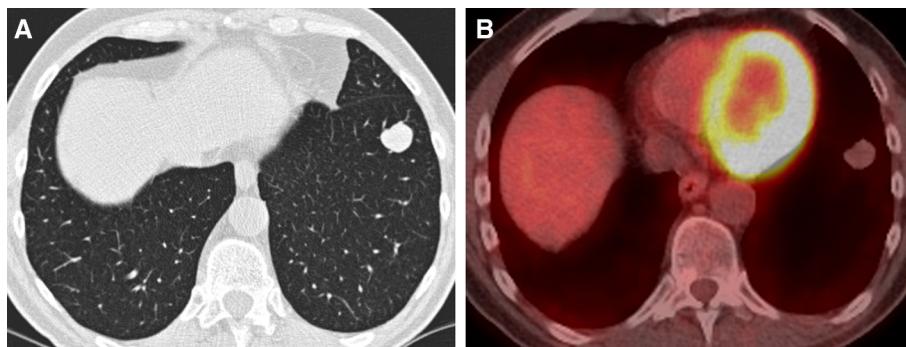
Lung Reporting and Data System (LU-RADS) 4A nodule (suspicious, low risk of malignancy). (A) Unenhanced computed tomography (CT), demonstrating a 17-mm, well-defined, roughly spherical, solid nodule with minimal lobulation. The nodule was thought to represent a hamartoma but macroscopic fat could not be confirmed by CT. The lesion was categorized as LU-RADS 4A (suspicious; low risk of malignancy). (B) Fluorodeoxyglucose positron emission tomography (PET), demonstrating no uptake. The negative predictive value of the PET for a low-risk solid nodule in a patient who is high risk is very good. In conjunction with the surgeon, the patient chose not to have the nodule resected. After 2 years of stability, it is reclassified as LU-RADS 2 (benign nodule). This figure is available in colour online at <http://carjonline.org/>.
